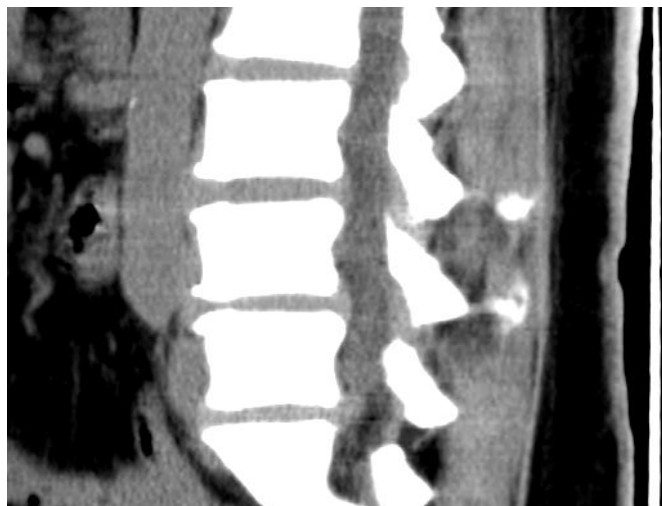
Sagittal CT image showing large L5-S1 disc protrusion with degenerative disc changes at L4-5 and L5-S1 and mild bulging of the L4-5 disc.
